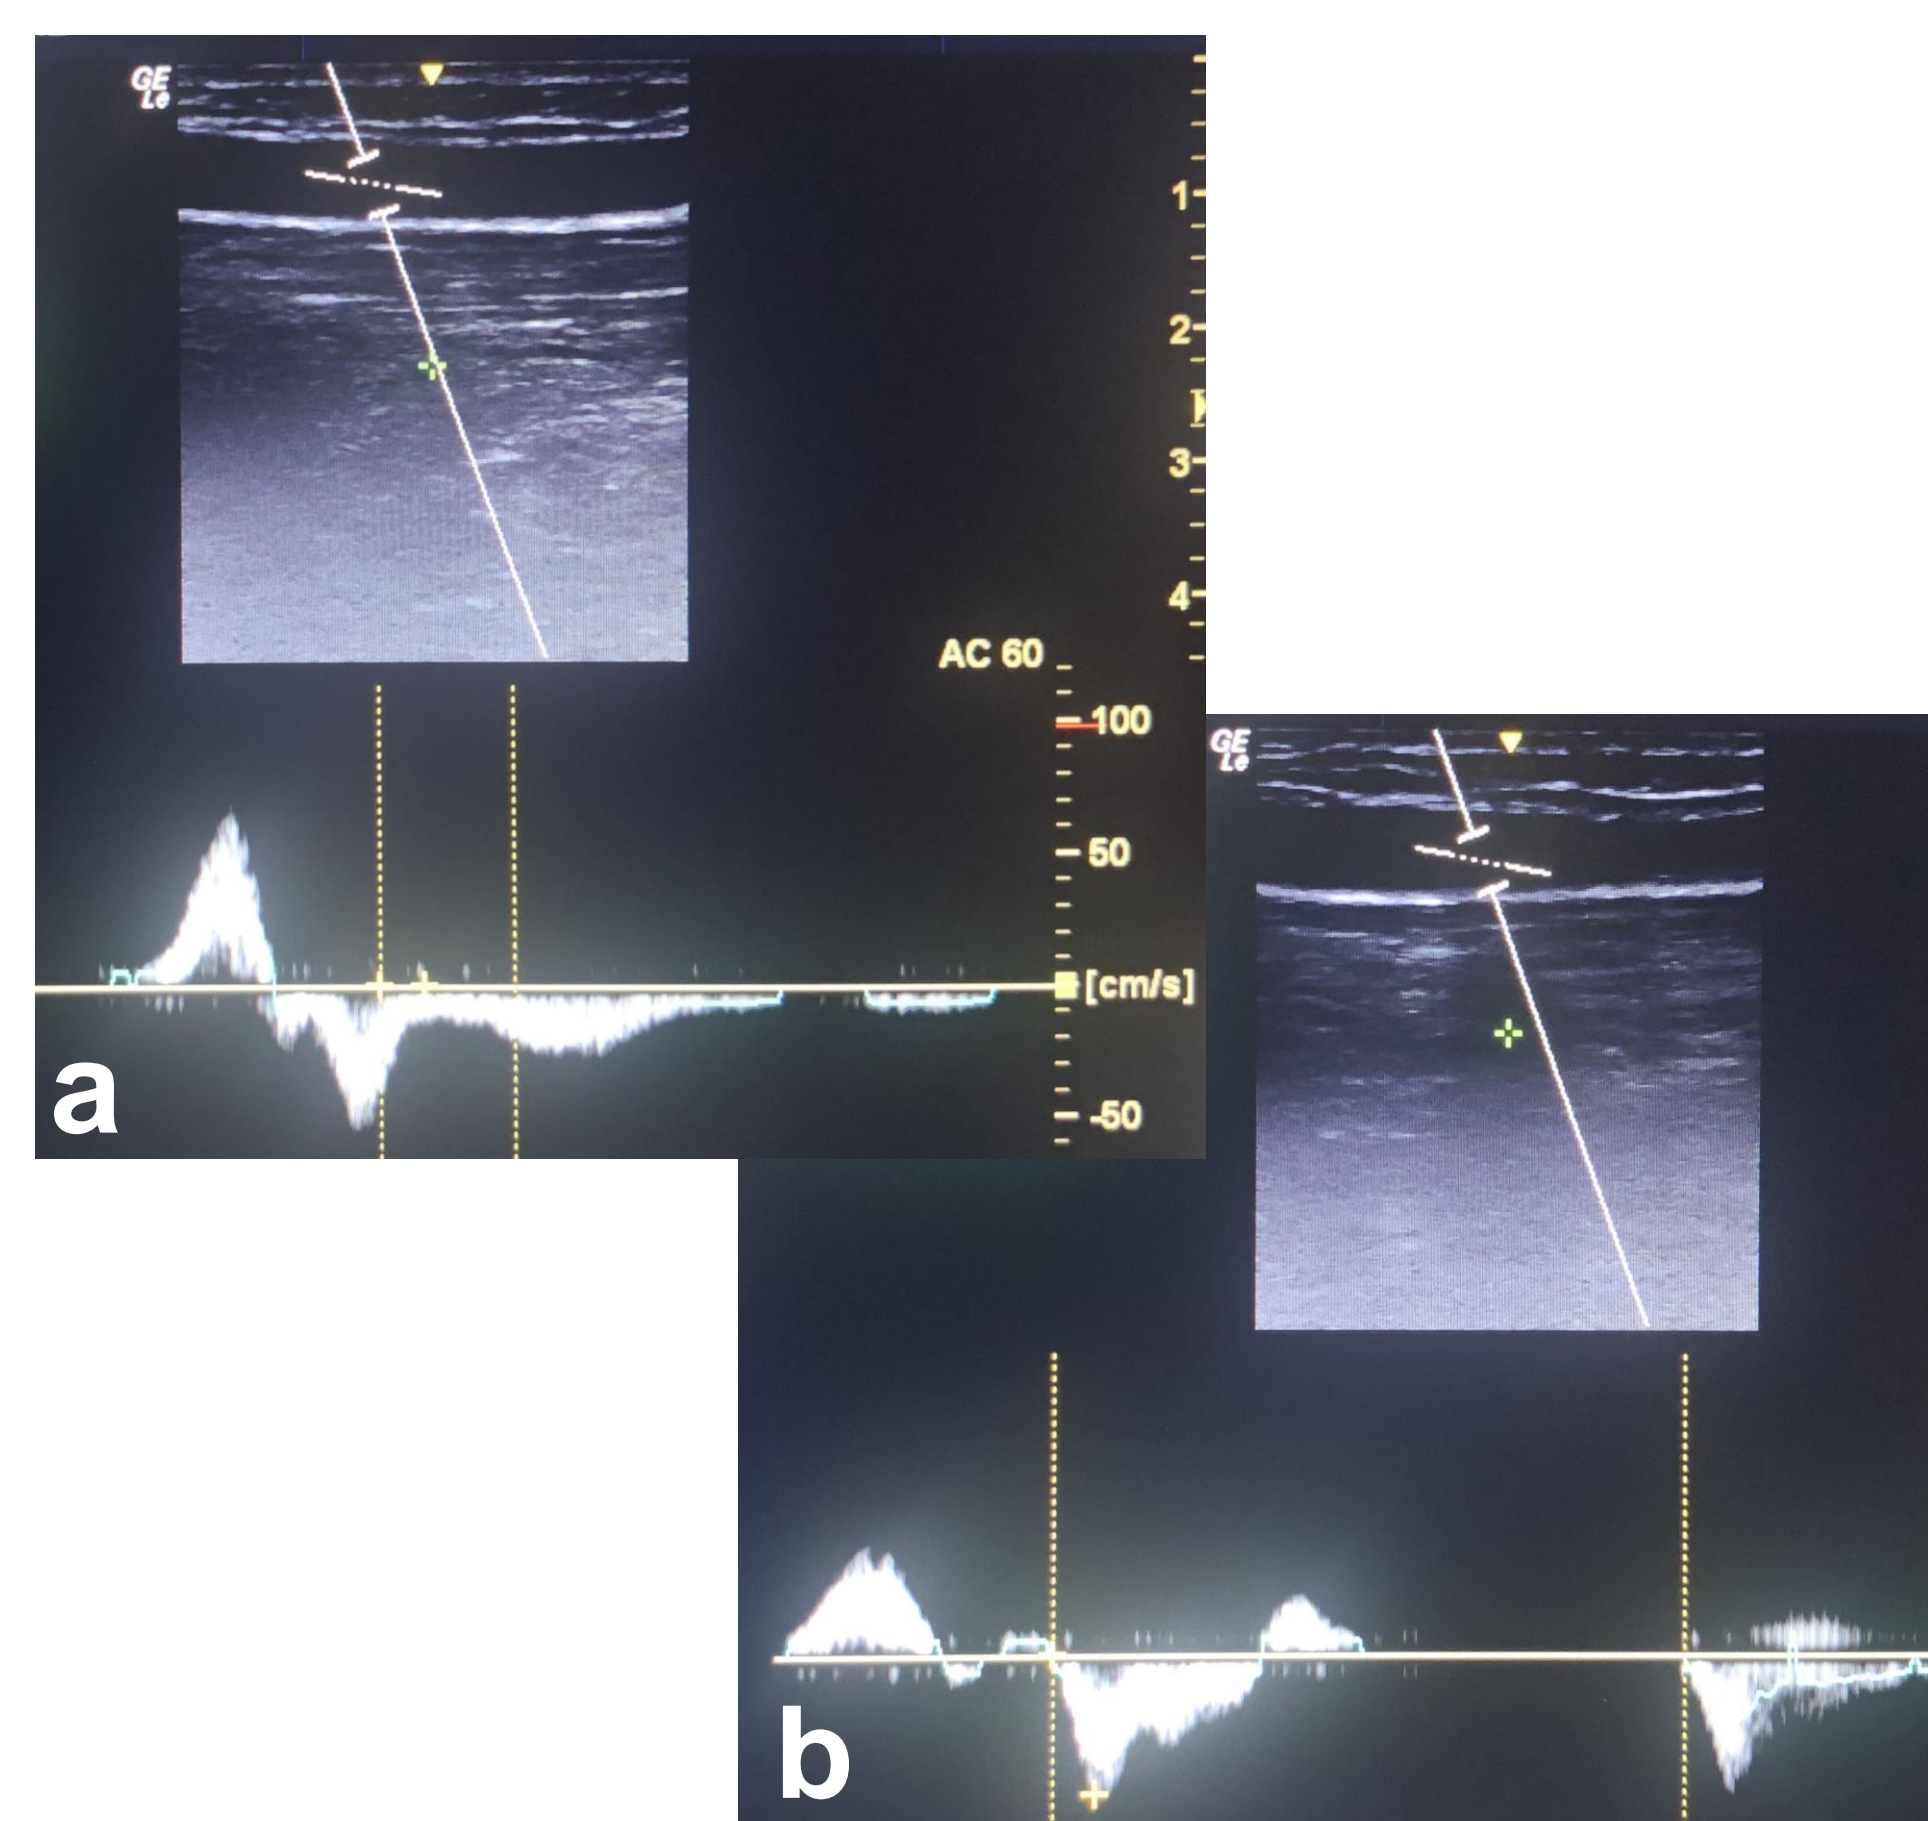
Patient B ultrasonographic exam at the proximally to the thigh posterior varicose collateral showing the elongated reflux pattern in (a) and the abolishment of the reflux during suppression test by manual compression of the collateral
